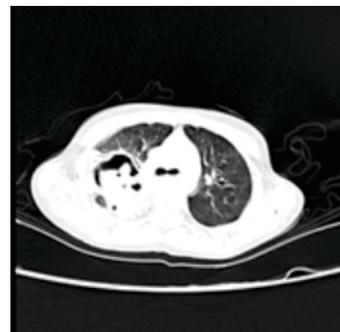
CT Thorax scan of patient on discharge
